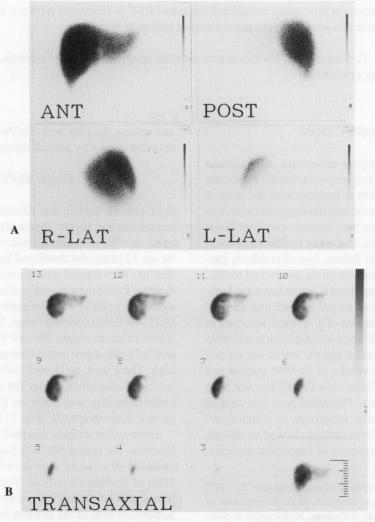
Tc-99m tin colloid planar (A) and SPECT (B) images show no splenic activity.
